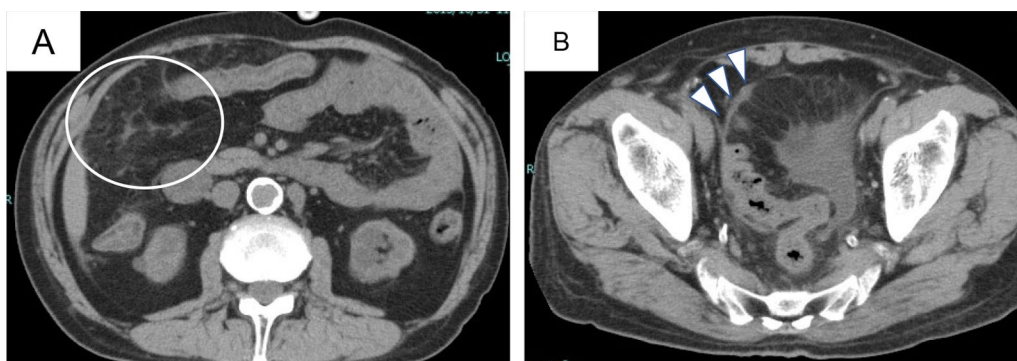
Abdominal computed tomography images on the thirty-first day after admission. A White circle indicates increased mesenteric fat tissue concentration. B White arrowheads indicate thickening of the visceral peritoneum
